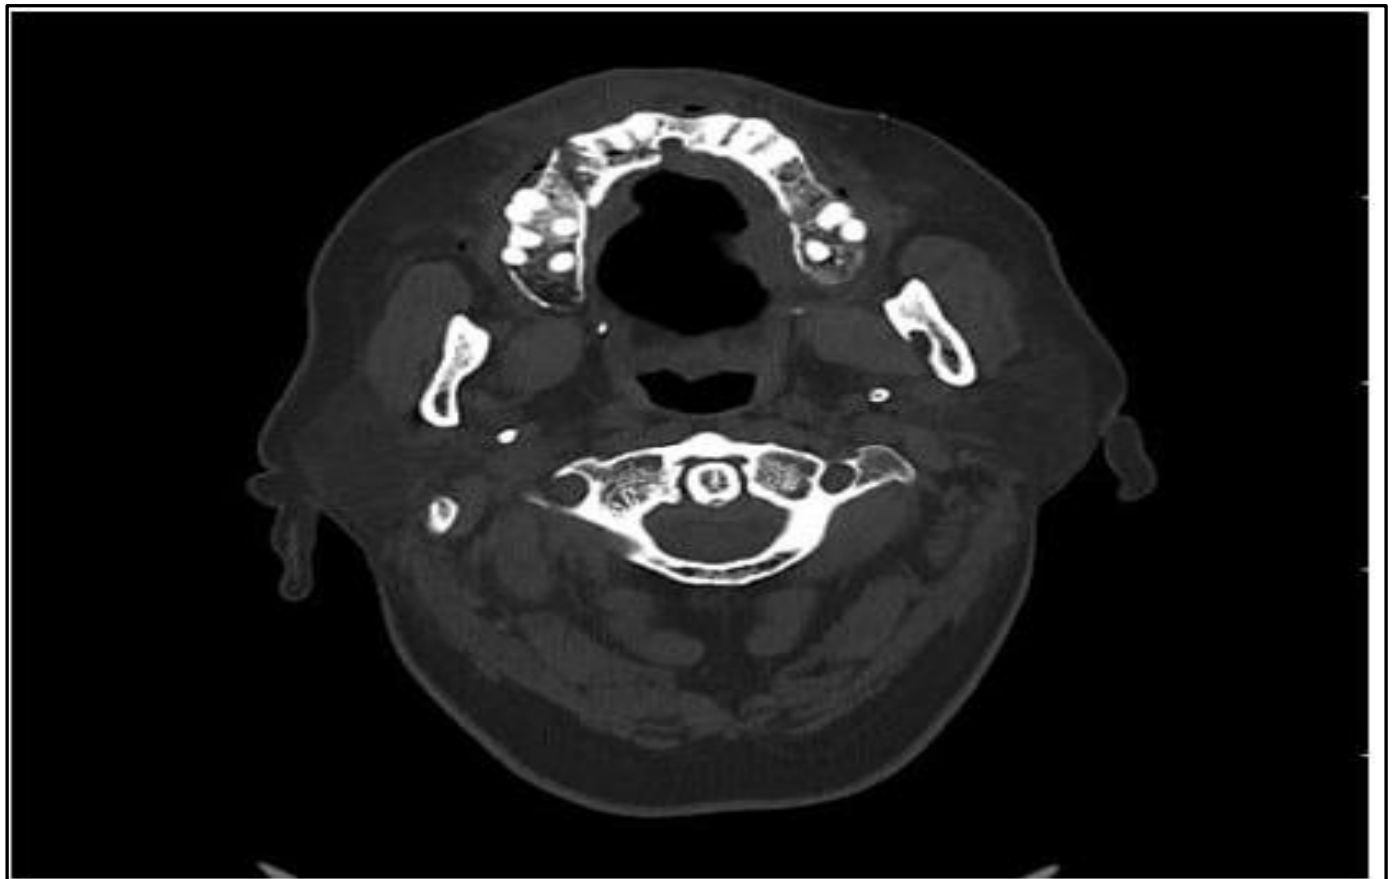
CT Image (Axial Cut) Showing Right Palatal Bone Fracture
